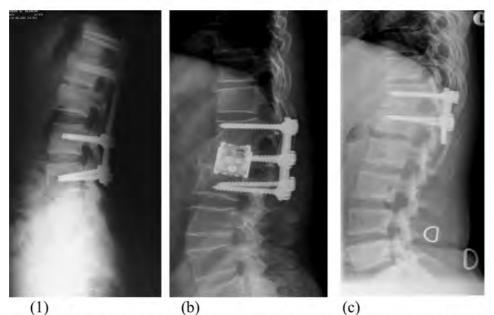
Radiography of three cases of thoracolumbar fractures constructed thoracoscopically. (a), and (c) were reconstructed using harvested iliac bone graft. (b) was reconstructed using expandable corpectomy cage filled with cancellous bone.
